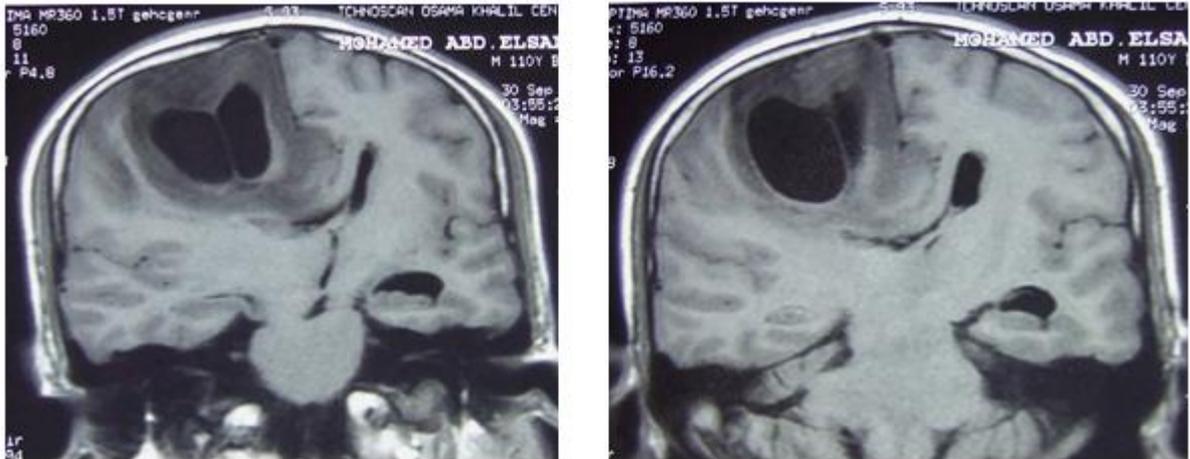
Preoperative T₁ MRI brain with contrast
